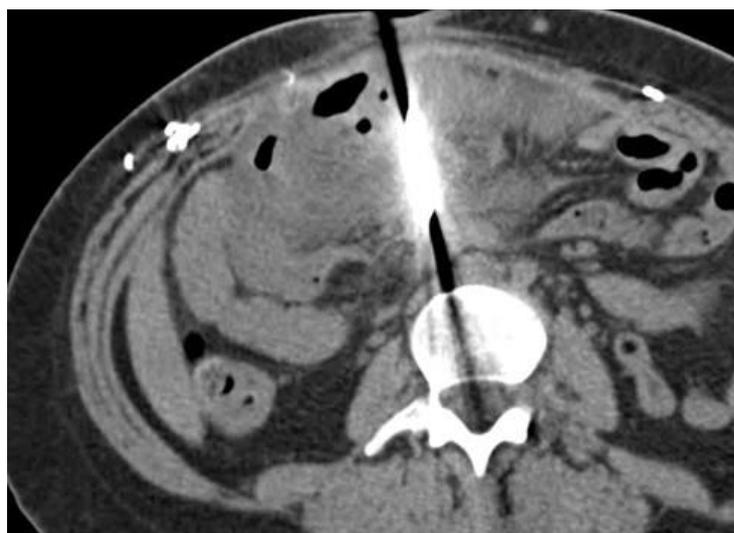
CT image of penetrating bowel injury with knife (17)
